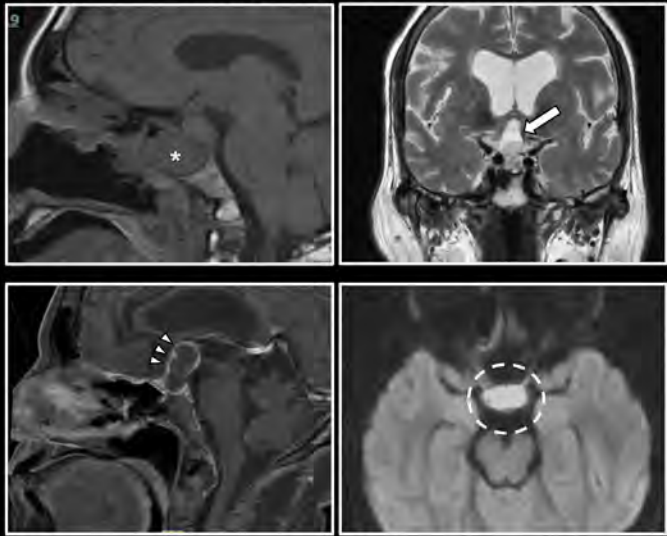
Pituitary abscess: characteristic MR imaging features: (A) Sagittal T1WI shows a sellar lesion with central hypointensity and a thin rim (*). (B) Coronal T2W demonstrates a hyperintense core (arrow) (C) Postcontrast T1WI reveals smooth peripheral rim enhancement without internal enhancement (arrowheads). (D) Axial DWI shows marked diffusion restriction, confirming purulent content (circle).
